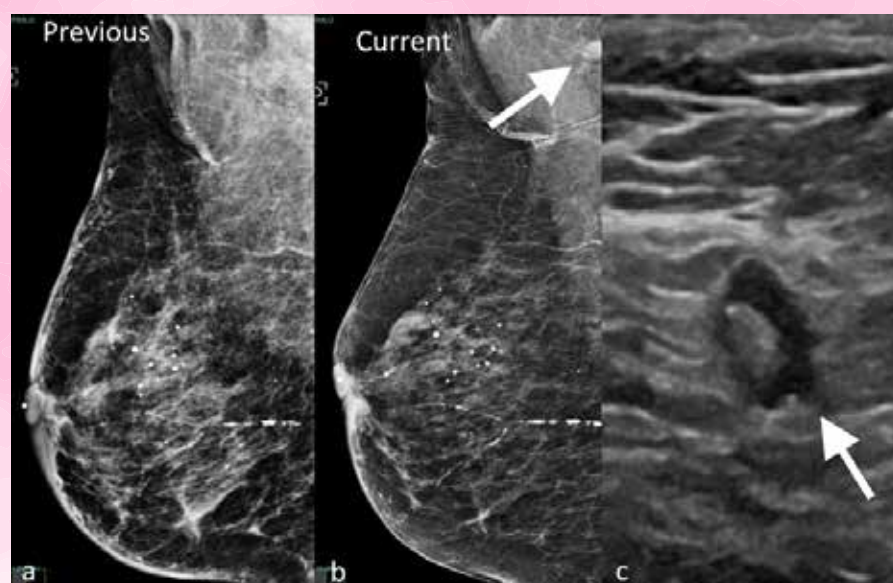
Previous a. and current b. MLO views of the left breast showing interval development of a left axillary lymph node (arrow). c. Ultrasound image of the left axilla confirms the presence of a non-enlarged lymph node with asymmetric cortical thickening and margin irregularity (arrow). Biopsy of the lymph node confirmed metastatic invasive ductal cancer.
